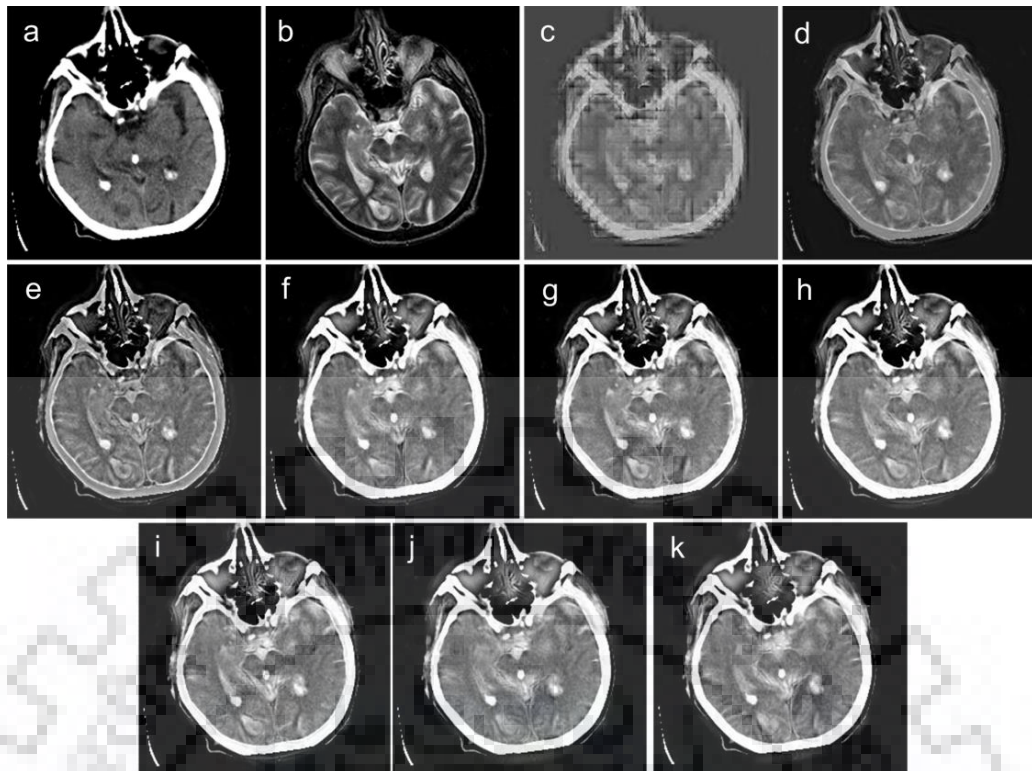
Comparative analysis of visual results obtained by different fusion methods applied to the image pair-4 (a) CT image (b) MR image. The fused image provided by the (c) Method 1 (d) Method 2 (e) Method 3 (f) Method 4 (g) Method 5 (h) Method 6 (i) Method 7 (j) Method 8 (k) Proposed NSST-MIF method
